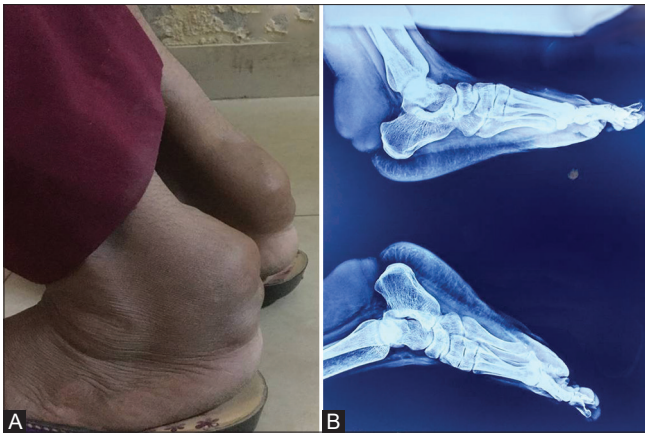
(A and B): Photograph of bilateral ankles revealing swelling along the posterior aspect of both ankles (A) with corresponding lateral radiograph of both ankles revealing soft tissue radio-opacities posterior to calcaneal bones and tibia in the region of Achilles tendons (B)
